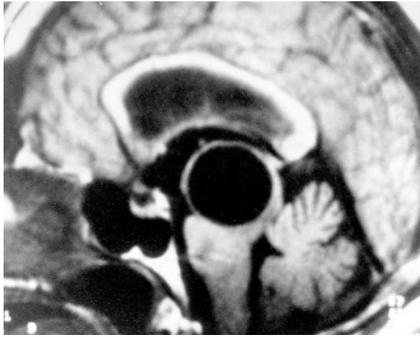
Sagittal T1-weighted MRI. Mesencephalic hydatid cyst
